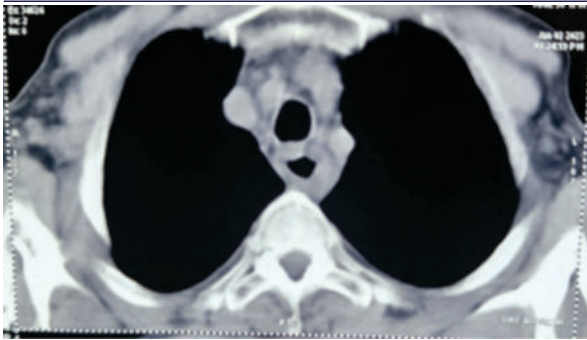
Fig II Computed Tomography (CT) Of Chest Showing Diffuse Esophageal Wall Thickening And Surrounding Edema
